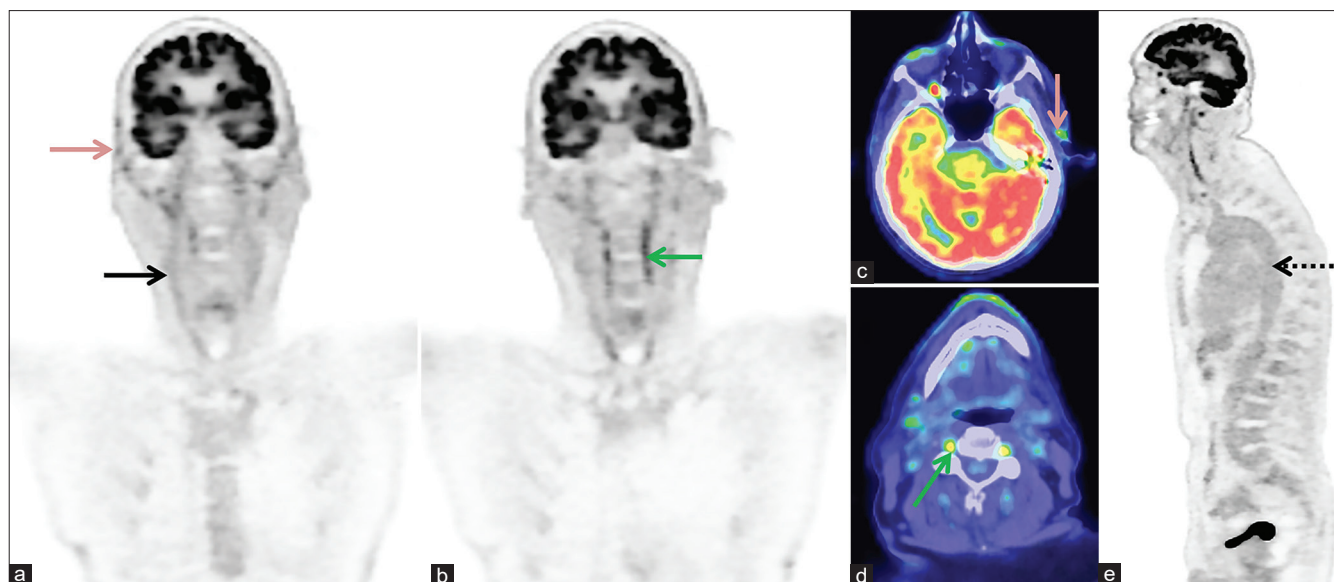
Coronal positron emission tomography only images anteriorly (a) and posteriorly (b) and axial-fused positron emission tomography/computed tomography images of the neck (c) and head (d) show increased fluorodeoxyglucose uptake in external carotid arteries (solid black arrow, a), bilateral superficial temporal arteries (pink arrows, a and c), and vertebral arteries (green arrows, b and d). The aorta is normal with fluorodeoxyglucose uptake within the range of normal for a modern silicon photomultiplier digital positron emission tomography scanner (dotted black arrow, e)
